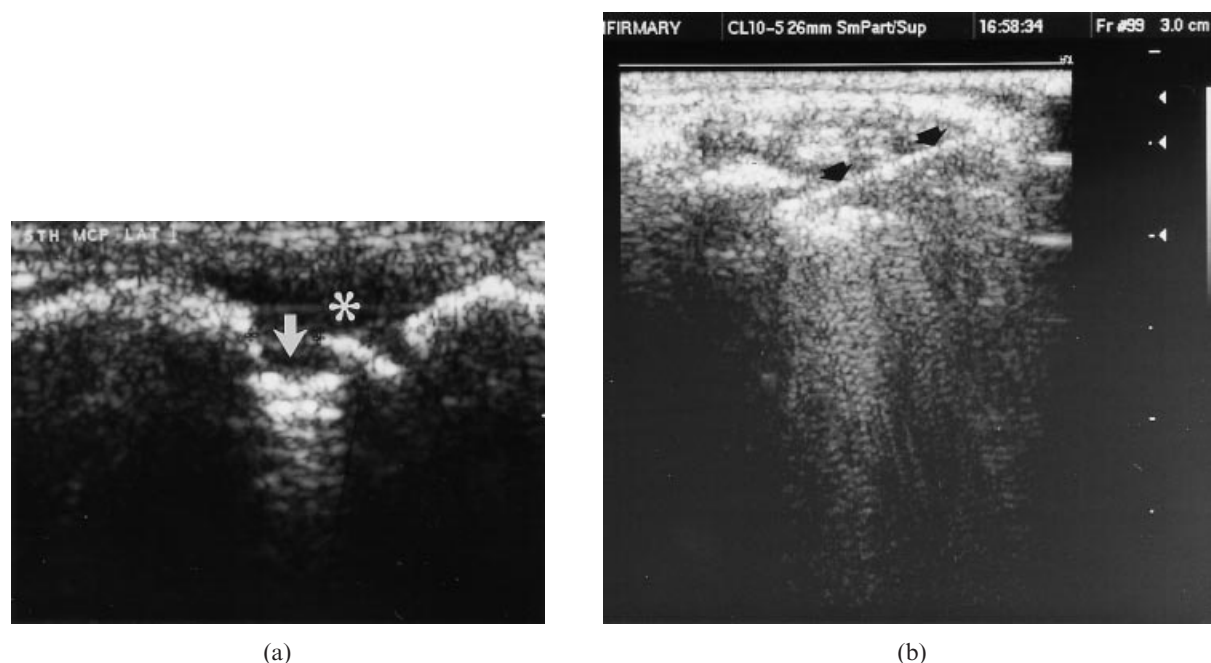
(a) Longitudinal ultrasound image of the lateral aspect of the fifth metacarpal head demonstrating a small cortical erosion (arrow) and overlying synovial thickening (\*). (b) Same as (a), but now a needle has been passed so that its tip lies within the base of the erosion.
